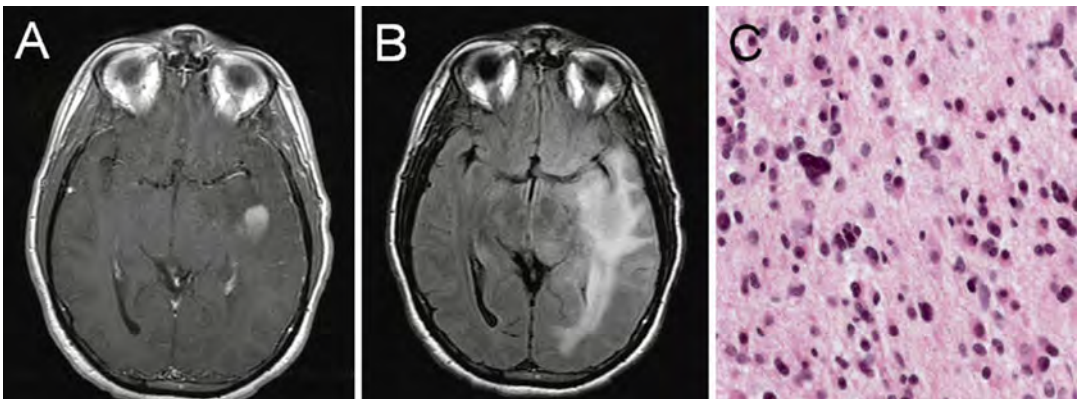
T1 axial post-gadolinium-enhanced MRI (a) and T2 axial fluid-attenuated inversion recovery (b) images showing a left temporal anaplastic astrocytoma with a
